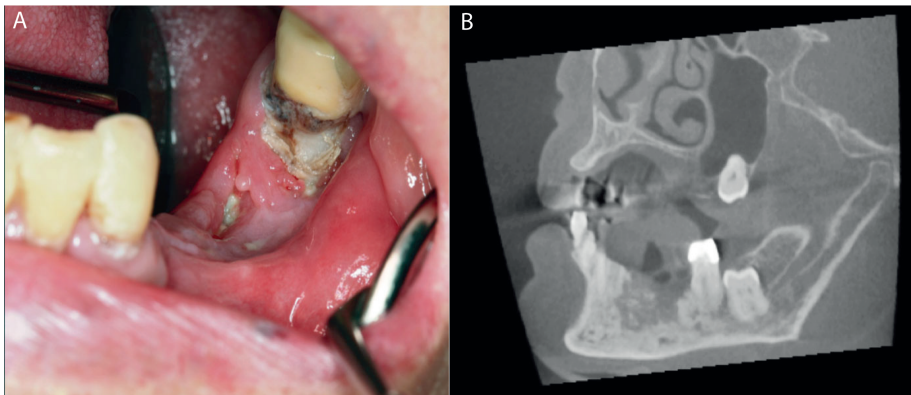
(A). ONJ patient with osteoporosis treated with alendronate for >3 years. A small area of exposed bone is observed in the region of the first molar and close to the second molar on the left side of the mandible. (B). A cone-beam computed tomography scan revealing that the lesion extends beyond the alveolar bone.
